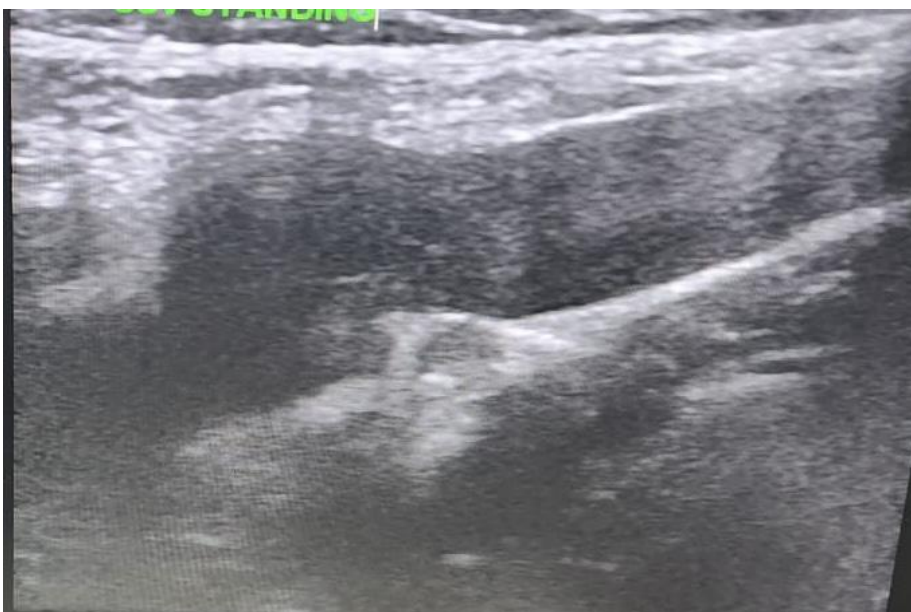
(B): Ultrasound of the saphenopopliteal junction (SPJ) during valsalva showing patent junction with dilated saphenous vein.
